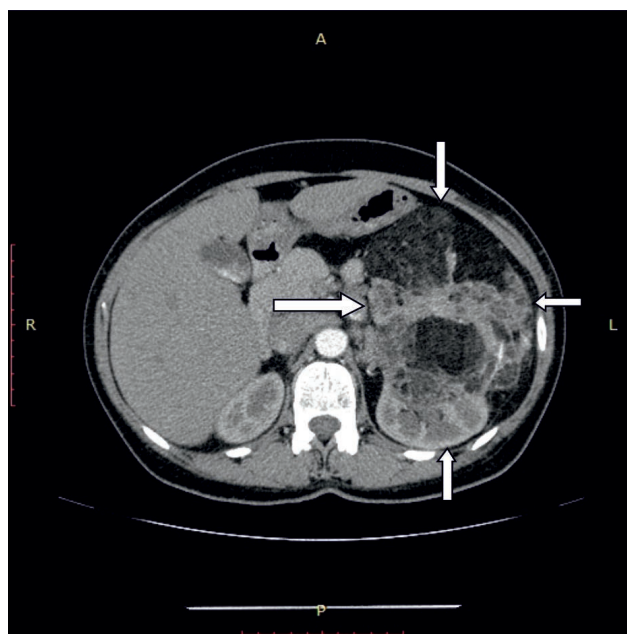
Computed tomography scan suggesting giant renal angiomyolipoma.
